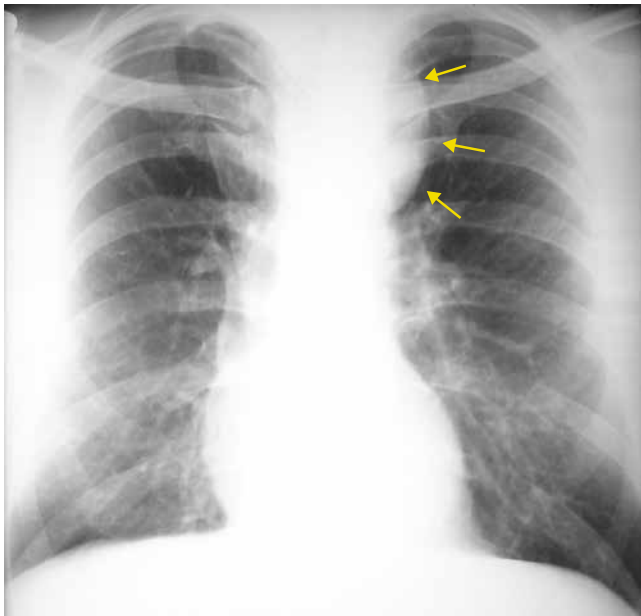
Chest radiograph. Widening of the upper chest mediastinum (arrows)
